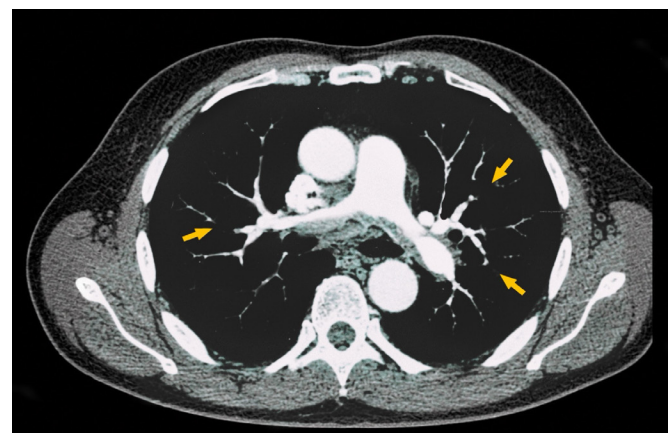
Computed tomography pulmonary angiography (CTPA) showing chronic thromboembolic disease involving bilateral subsegmental pulmonary arterial branches (yellow arrows), suggestive of chronic pulmonary thromboembolism.
